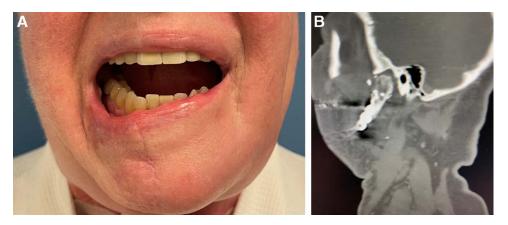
Excursion at 6-months improved from severe baseline trismus. A, Six-month postoperative photograph. B, Radiographic bony union and neo-condylar seating at 6 months.
